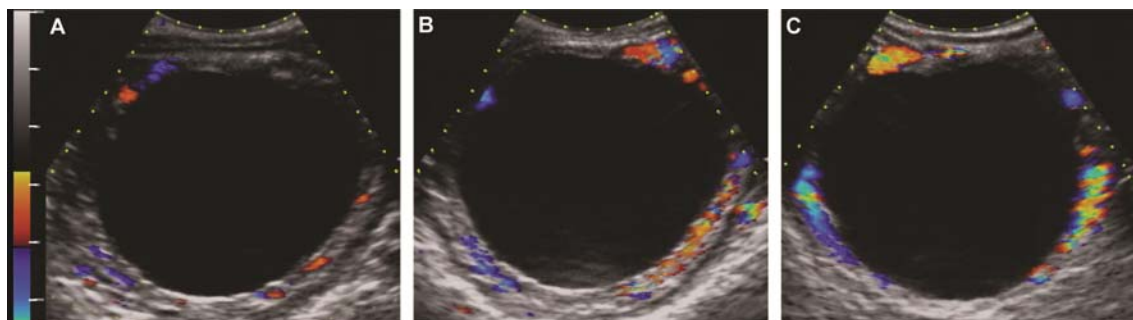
Sequential color-Doppler ultrasonograms of preovulatory follicles of one mare at 48 (A), 40 (B), and 24 (C) hours before ovulation. Note the increase in color-Doppler signals (amount of color dots and intensity) as the follicle matured (left to right). Most of the color-Doppler signals are located within or extend beyond the width of the anechoic band of the follicle wall. Adapted from Gastal et al. (2006a).
